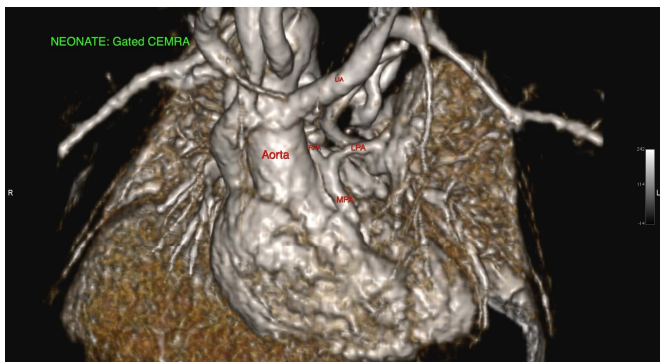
Volume rendered display in a 6 day old female with pre-test diagnosis of pulmonary atresia. Gated ferumoxytol CEMRA confirms the presence of native main and branch pulmonary arteries, presumed not present before the MRI, as well as multiple collaterals. The diameter of the left pulmonary artery (LPA) is 1 mm.
